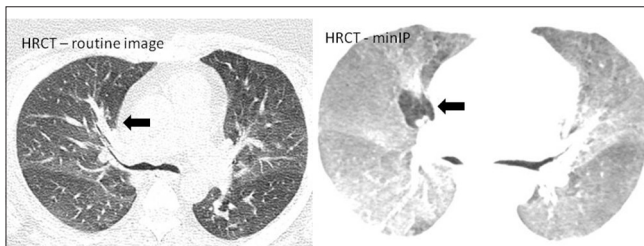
Comparative routine and minimum-intensity projection images of high-resolution computed tomography lungs in transverse plane showing areas of hypoattenuation (arrows) in this patient with airway disease. The areas of hypoattenuation are more conspicuous on minimum-intensity projection image
